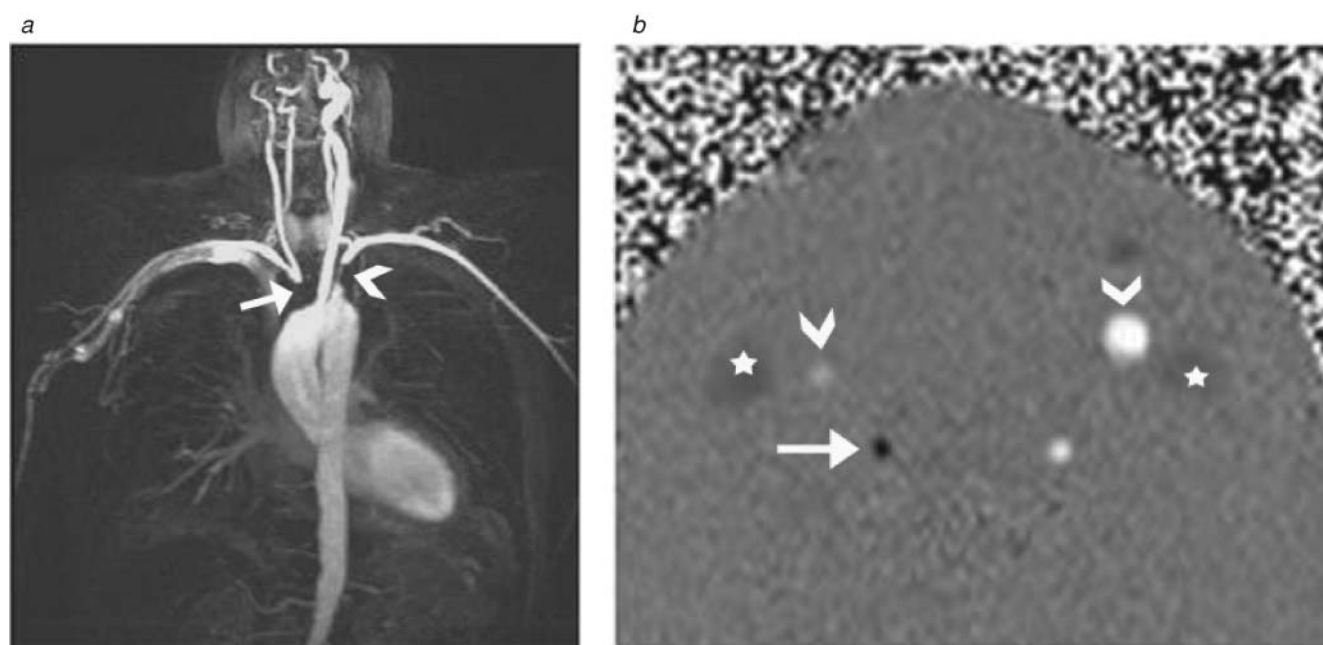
A 63-year-old female presents with lightheadedness and dizziness, particularly when grocery shopping. (a) Coronal maximum-intensity projection from a high-resolution contrast-enhanced thoracic aortic magnetic resonance angiogram demonstrates an occlusion of the right innominate artery (arrow) and a focal tight stenosis of the left subclavian artery (arrowhead). (b) Axial phase contrast magnetic resonance image obtained for flow directional information. Note that the antegrade flow is white in color and retrograde flow is black in color. There is forward flow (white) within both carotid arteries (arrowheads); note the smaller caliber of the right carotid artery compared with the left. There is reverse or retrograde flow (black) within the right vertebral artery (arrow) consistent with a right subclavian artery steal phenomenon. Note the normal retrograde flow within both internal jugular veins (stars).
